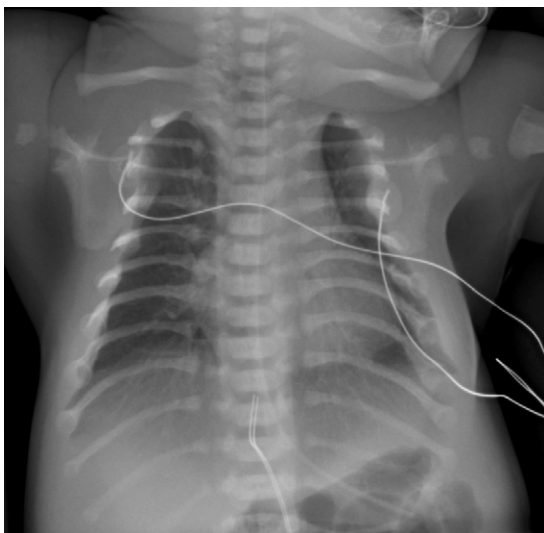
Short ribs in a neonate with Jeune asphyxiating thoracic dysplasia. Frontal chest radiograph shows markedly short and horizontally oriented ribs. The clavicles are high in position, and premature ossification of the proximal humeral epiphyses is seen.
